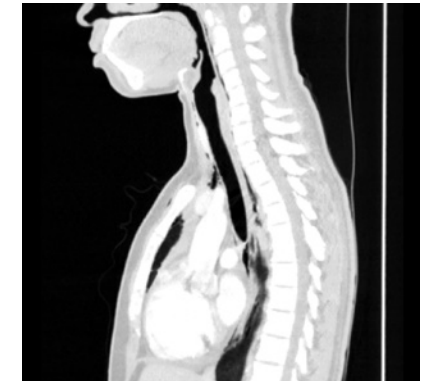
IV contrast-enhanced CT neck and thorax in the sagittal plane, demonstrating the extent of surgical emphysema from the nasopharyngeal region superiorly to the posterior mediastinum inferiorly.
